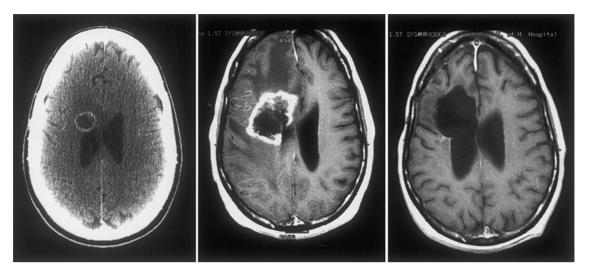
Recurrent high grade ganglioglioma after fractionated radiation. Axial, contrast enhanced CT on the day of treatment (left), and axial, T1 weighted, gadolinium enhanced MRI from 5 months (center) and 23 months (right) after radiosurgery. The patient received 17 Gy to the 84% isodose surface of a 5.7 cc mass.
